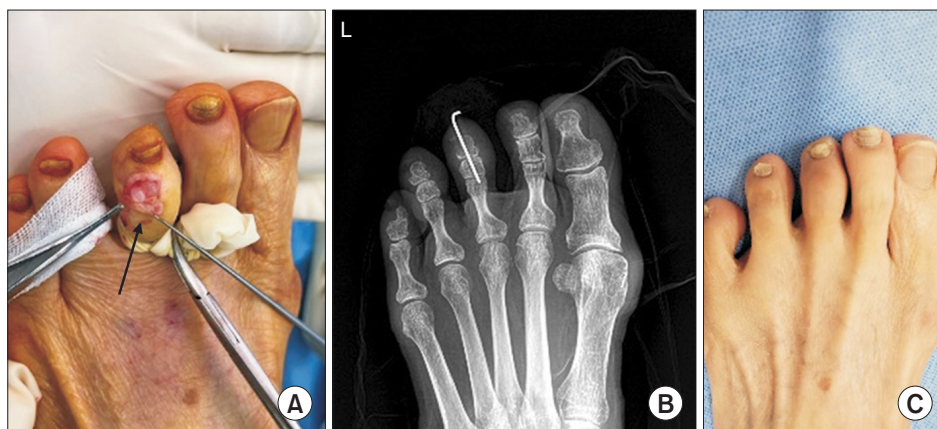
(A) Ganglion cyst of the third toe adjacent to the distal interphalangeal joint (black arrow). (B) Postoperative X-ray. (C) Postoperative 1-year follow-up.
